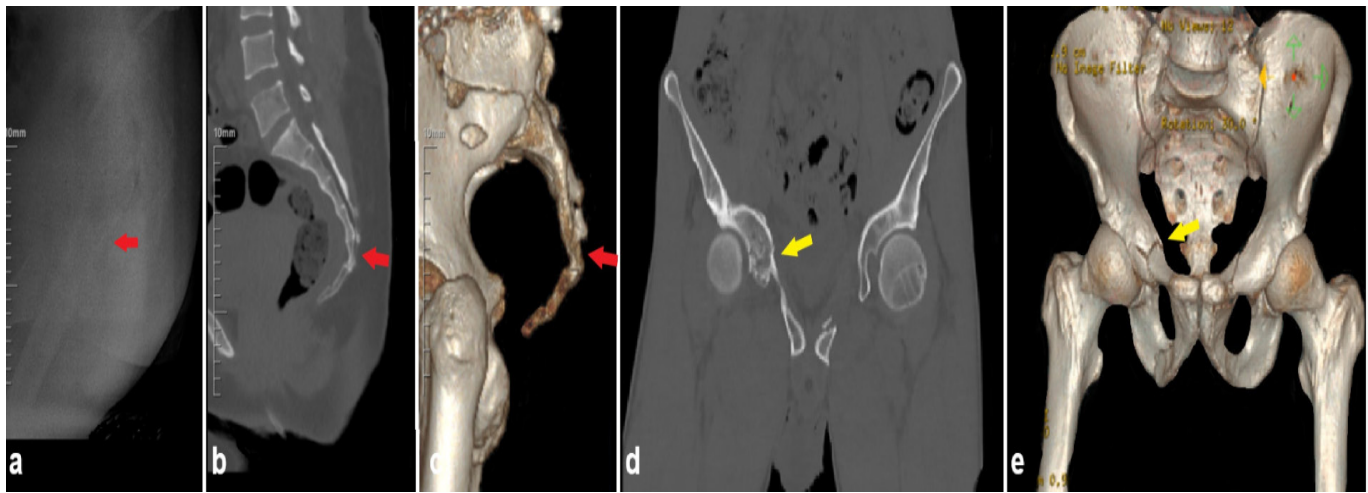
X-ray lateral view oblique radiolucency in the first coccygeal segment suggestive of a fracture (red arrow) (a), sagittal bone window reformat computed tomography fracture of first coccygeal segment (red arrow) (b), 3-dimensional computed tomography fracture of first coccygeal segment (red arrow) (c), coronal bone window reformat computed tomography right acetabulum segmented non-displaced fracture (yellow arrow) (d), 3-dimensional computed tomography right acetabulum segmented non-displaced fracture (yellow arrow) (e).
